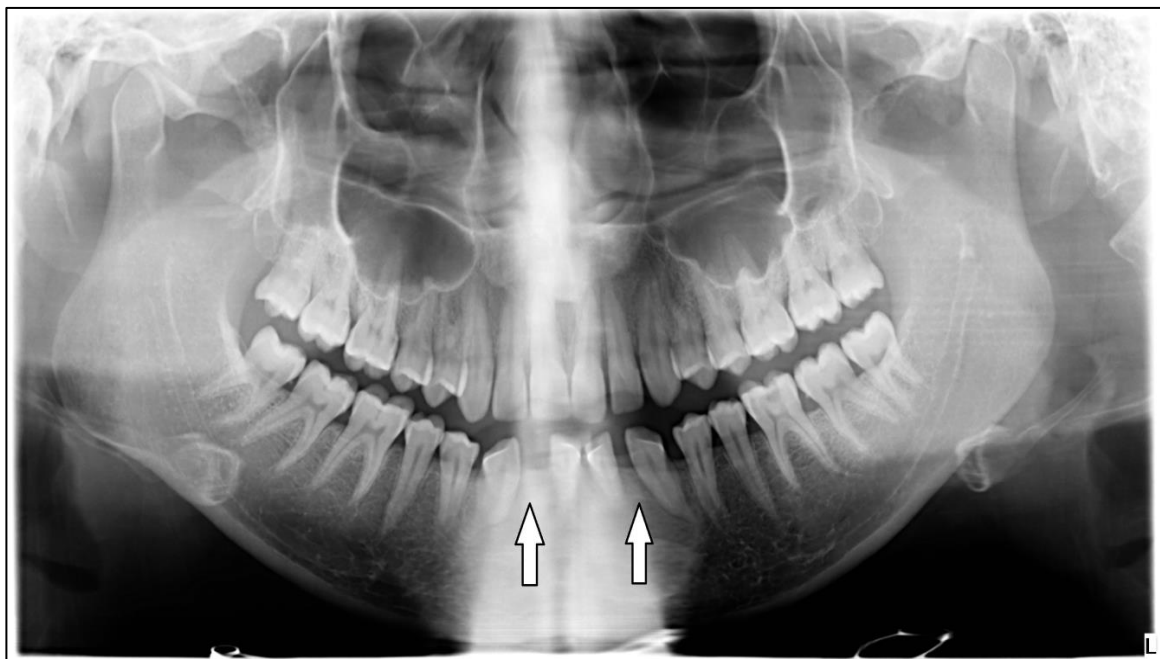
A Panoramic radiograph (O.P.G) showed bilateral congenitally missing lower lateral incisors.
